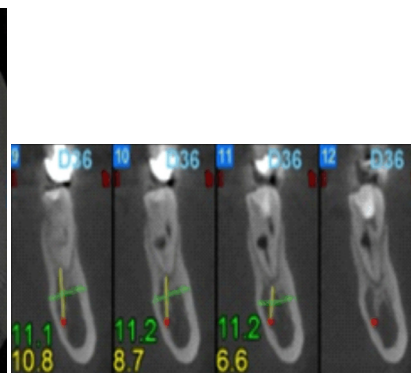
Preoperative CBCT scan (coronal view of mesial root in tooth 36).
